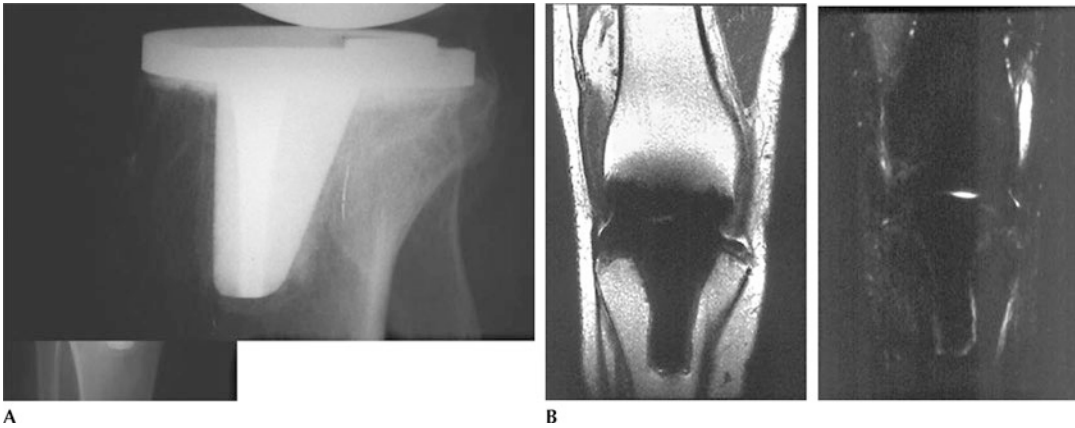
Loose component. (a) Identification of a lytic osseous defect, absence of bone trabeculae, and geographic demarcation make the diagnosis radiographically. (b) Additional tests such as magnetic resonance imaging and bone scans may also facilitate the diagnosis of loose components
